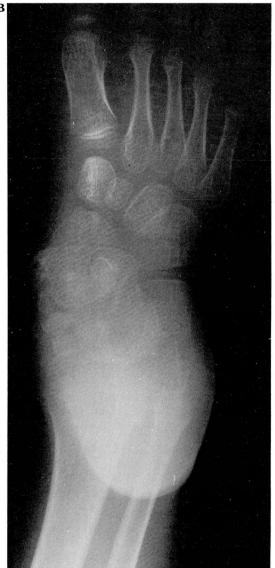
A and B. Oblique and lateral preoperative radiographs. Note the lobulated appearance of the protruding bony ossicles with resultant inferior displacement of the navicular relative to the talus.
